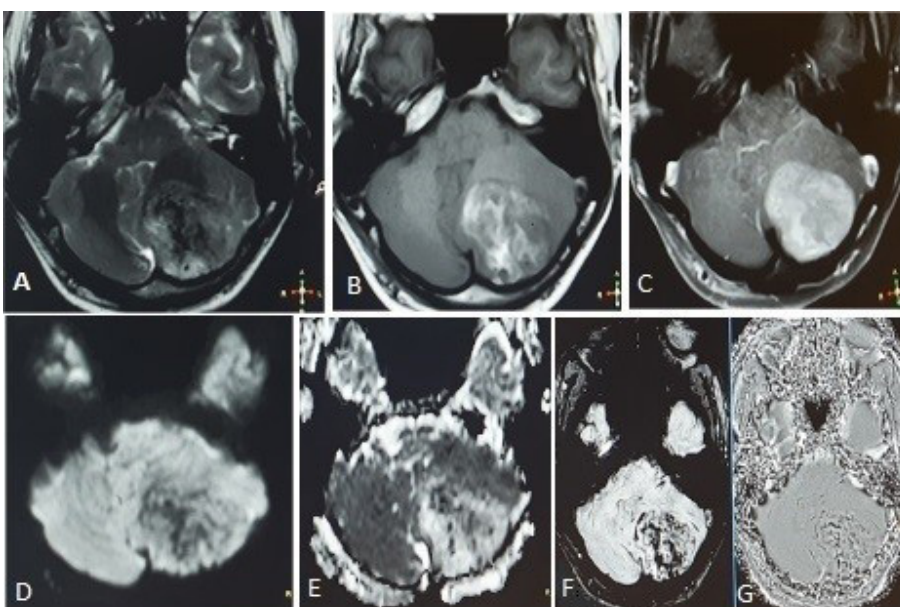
High-Grade Meningioma. (A) axial T2W, (B) axial T1W, (C) contrast-enhanced T1W, (D) DWI, (E) ADC map, (F) ITSS in SWI and (G) SWI phase images show a high-grade meningioma in left side of posterior fossa
